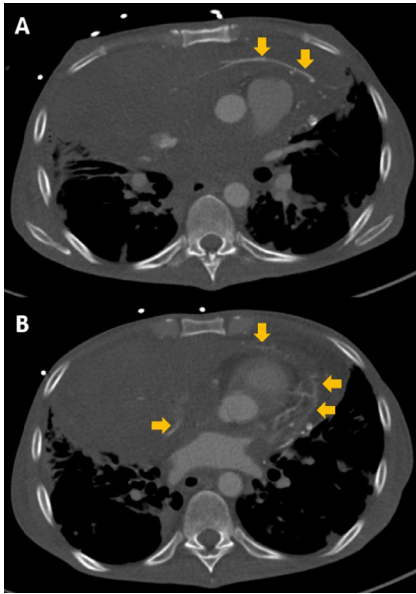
Pericardial collaterals (orange arrows) seen in chest computed tomography surrounding a large pericardial effusion of more than 3 cm, making pericardiocentesis nonfeasible in a patient with refractory Hodgkin lymphoma.
